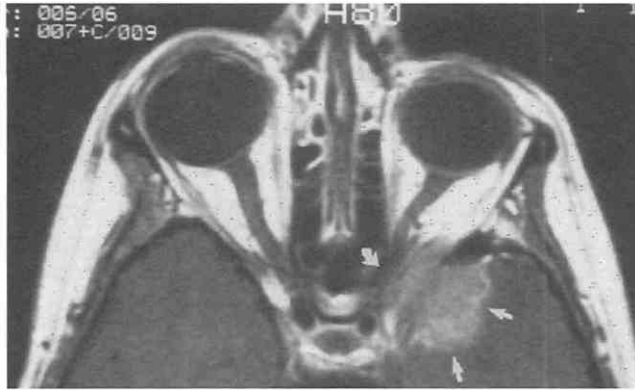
Axial T1-weighted MRI study with gadolinium shows left sphenoid wing meningioma (arrows), with compromise of the optic canal (curved arrow).
